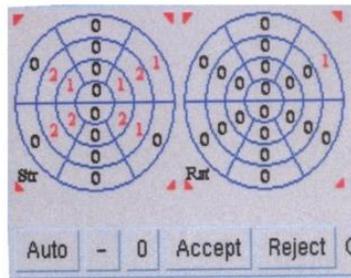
Myocardial scintigraphy- hypoperfusion of septum and lateral wall, very suspect multivessel disease, quantification on the left side (own source).
